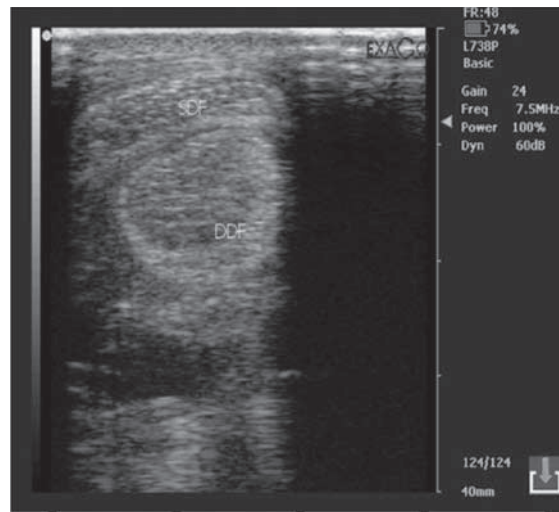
Ultrasound image on tenth day
